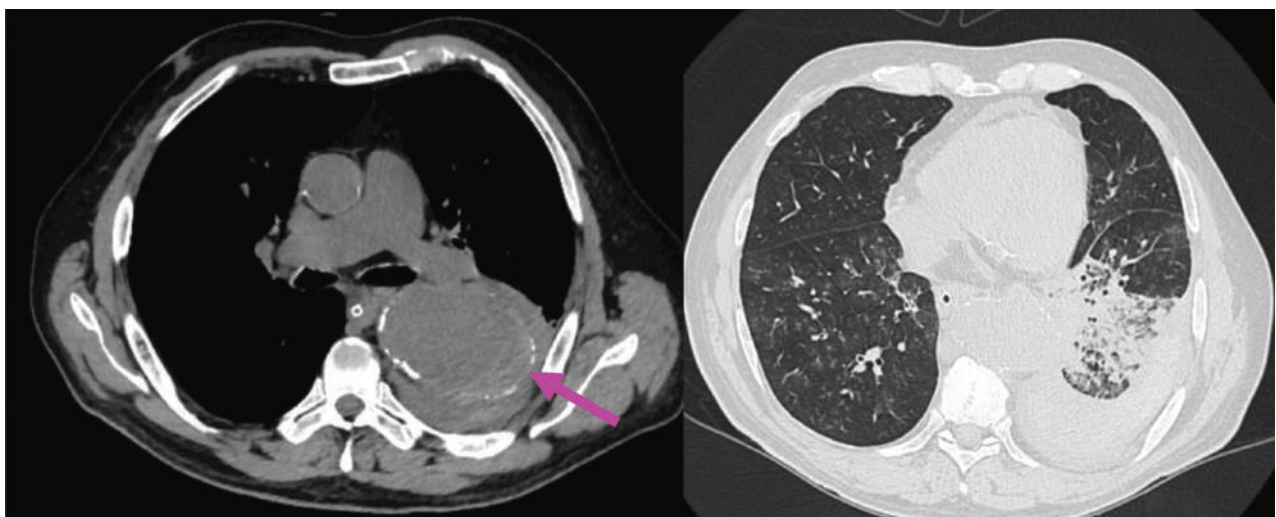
Native CT acquisitions - axial sections.
